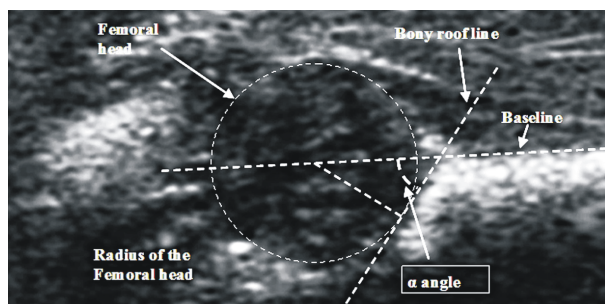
α Angle on the ultrasound image.
